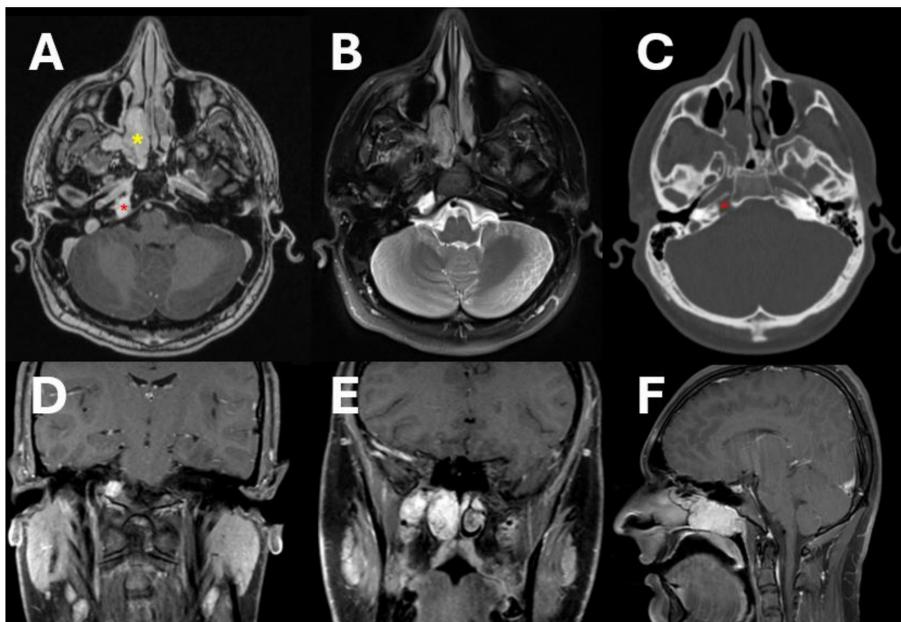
Imaging at presentation. Brain MRI axial T2WI (A) and axial T1WI contrast-enhanced (B) showing the JNA (yellow asterisk) in the right nasal cavity extending into right nasopharyngeal space and pterygopalatine fossa. Note the enhancing lesion in the right petrous apex (red asterisk), completely distinct from the JNA. Head CT axial bone window (C) showing a radiolucent bony lesion (red asterisk) at the right petrous apex. Brain MRI T1WI contrast-enhanced coronal (D, E) and sagittal views (F) showing the petrous apex enhancing lesion (D) and JNA (E, F).
